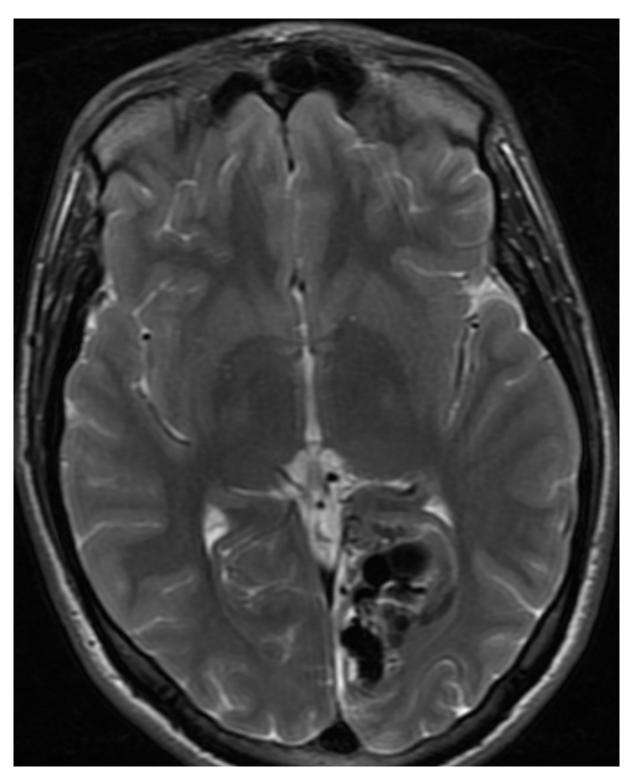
T2-weighted axial MR scan of left occipital AVM SM $\scriptstyle\rm II$
